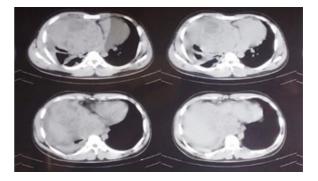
CT thorax shows Non-Hodgkin's Lymphomawith pleural effusion
